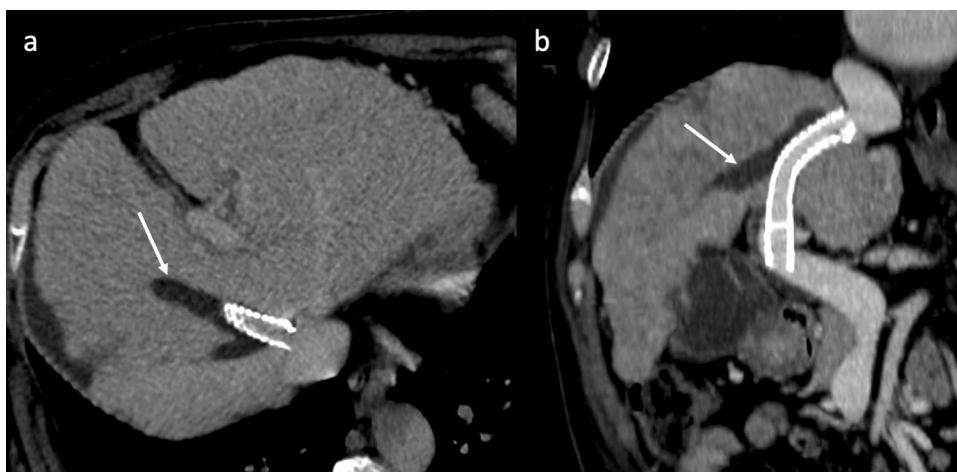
IVC thrombosis. Axial contrast-enhanced CT image on 3 min delayed phase shows a thrombus in IVC close to the distal edge of the TIPS in the right hepatic vein
